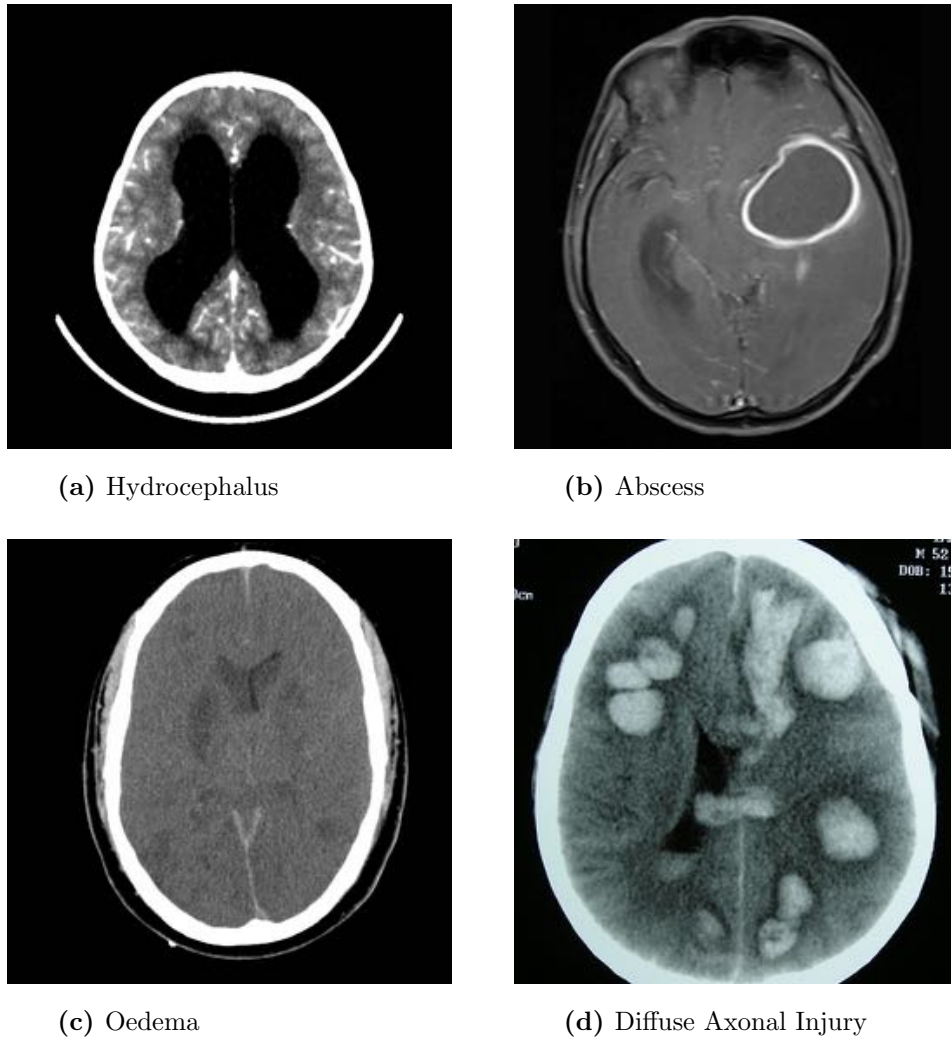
Cases seen on Brain CT
